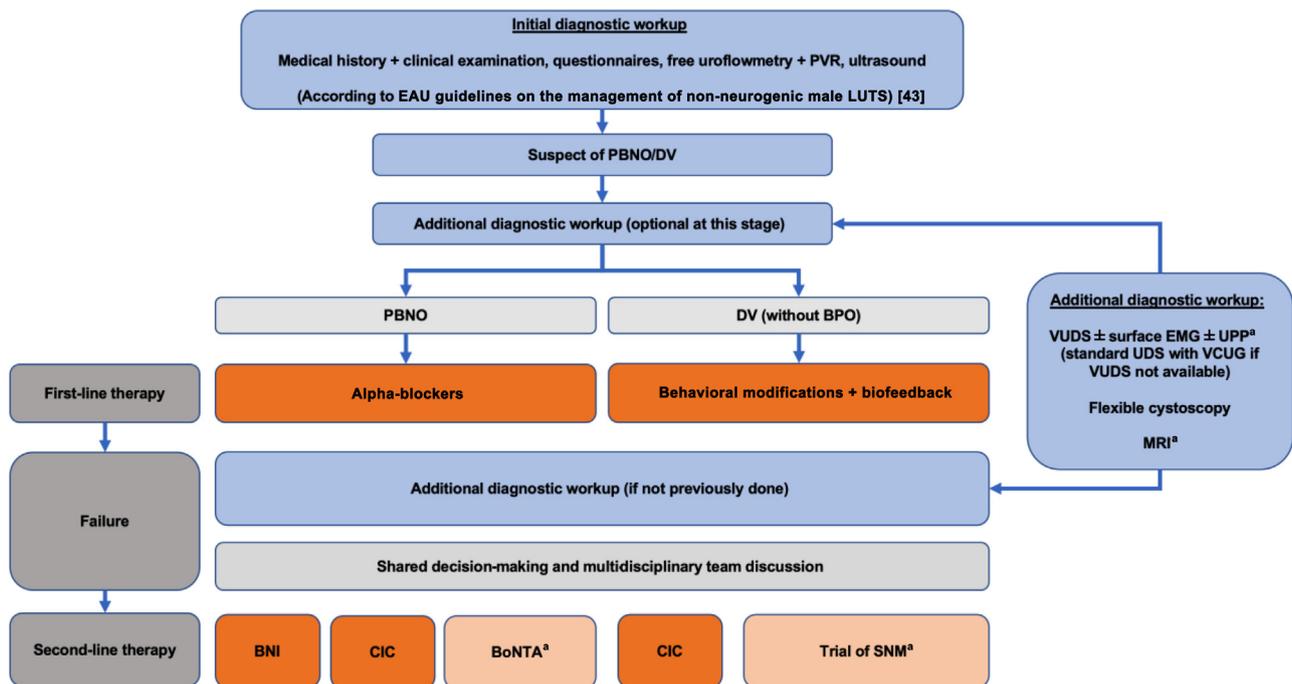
Algorithm summarizing the diagnosis and treatment of PBNO/DV in men aged 18–50 yr. BNI = bladder neck incision; BoNTA = onabotulinumtoxinA; BPO = benign prostatic obstruction; CIC = clean intermittent catheterization; DV = dysfunctional voiding; EAU = European Association of Urology; EMG = electromyography; LUTS = lower urinary tract symptoms; MRI = magnetic resonance imaging; PBNO = primary bladder neck obstruction; PVR = postvoid residual volume; SNM = sacral neurostimulation; UDS = urodynamics; UPP = urethral pressure profilometry; VCUG = voiding cystourethrography; VUDS = videourodynamics. ^a Experimental.
